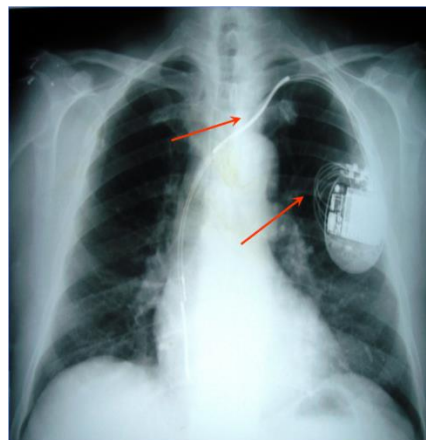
Chest X-ray at 4 months follow up shows RA lead at right subclavian and superior vena cava junction, RV lead in RA. Note the additional loops of the leads near the implant
